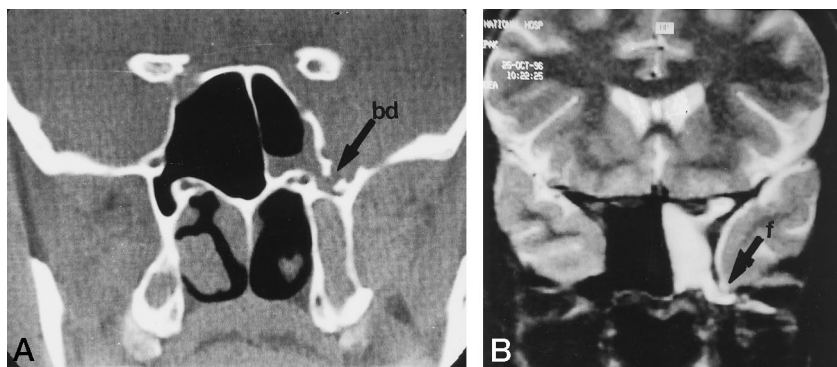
A, Plain high-resolution coronal CT section through the sphenoidal sinus shows a bone defect (bd) at the left lateral recess (arrow) with CSF-density fluid extending into the sphenoidal sinus.
